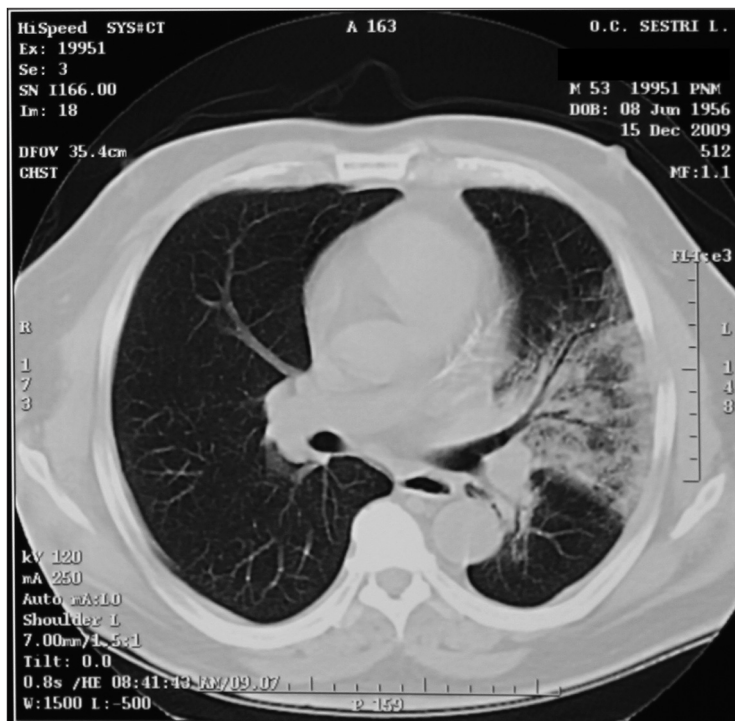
Chest CT: Prominent interstitial opacity with ground glass and air bronchogram.
